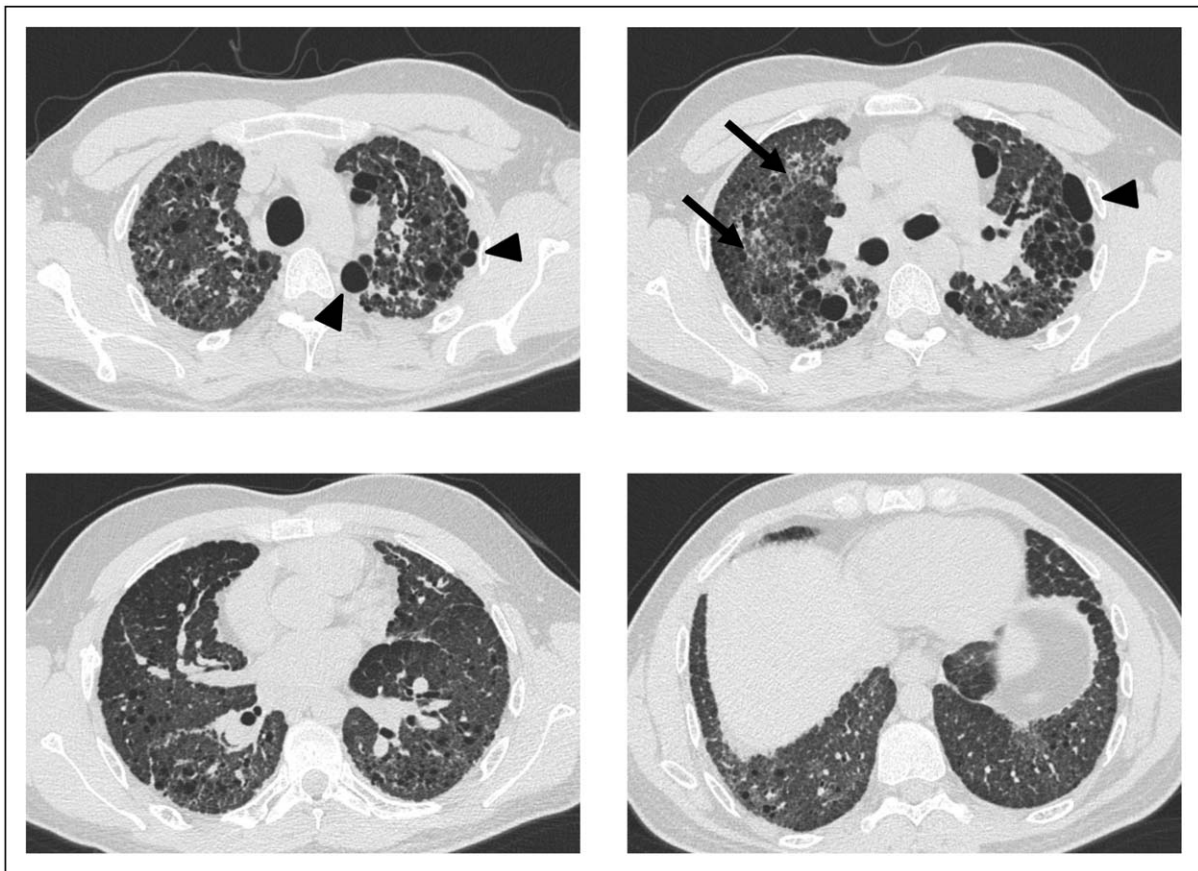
34-Year-old man with familial pulmonary fibrosis (his father and grandfather died of idiopathic pulmonary fibrosis at the age of 55 and 80 years, respectively). High-resolution computed tomography shows ground glass opacity (arrows), and centrilobular and paraseptal emphysema (arrowheads). These abnormalities predominate in the upper zones. This patient was found to carry heterozygous *TERT* (rs7712562) and *ATP-binding cassette subfamily A member 3* (rs138092785) mutations. Both mutations, however, are of uncertain functional and clinical relevance.
